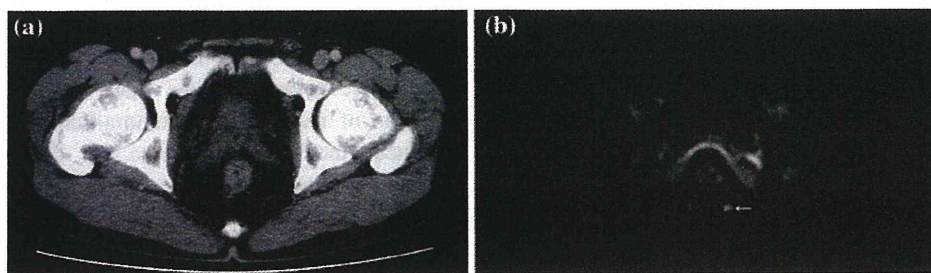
CT and DWI in a 64-year-old male patient with rectal cancer and lymph node metastasis. a CT showed the rectal wall thickness, but no findings of lymph node metastasis. b DWI clearly showed a
